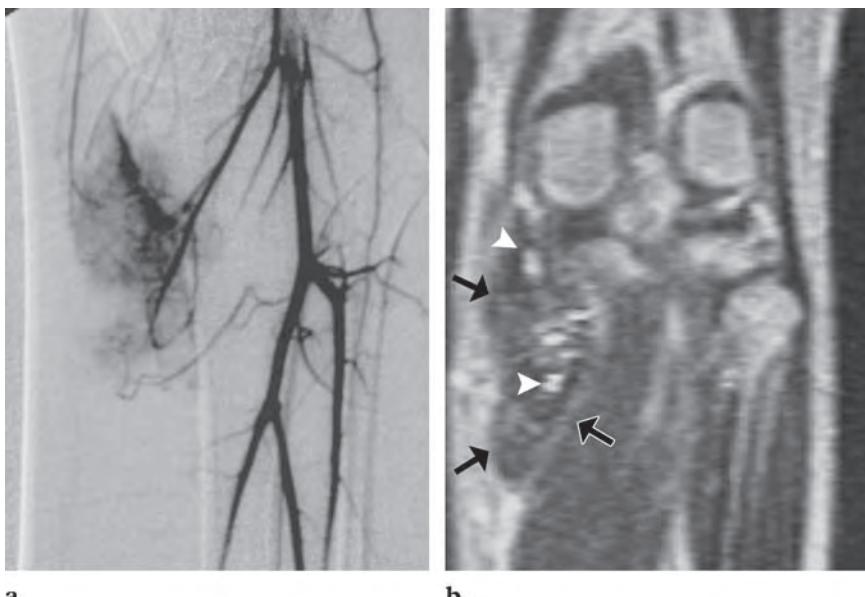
Localized extraarticular PVNB about the pes anserine bursa in a 26-year-old woman who presented with a slowly enlarging, soft-tissue mass in the medial knee. (a) Anteroposterior view from conventional late-arterial-phase arteriography shows prominent hypervascularity of the mass. (b) Coronal T2-weighted (2000/80) MR image reveals prominent low signal intensity of the mass (arrows), a finding that results from hemosiderin deposition. Small foci of high signal intensity (arrowheads) likely represent fluid surrounded by hemosiderin-laden tissue, an appearance similar to that of the cleft sign described in localized intraarticular PVNS.
